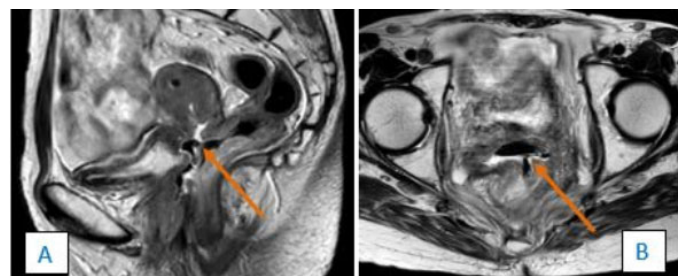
Pelvic MRI in T2-weighted sagittal (A) and axial (B) sections, in a 52-year-old patient with a history of cervical cancer treated with concomitant radio-chemotherapy, showing a fistulous pathway (arrow), communicating the rectum and the vaginal lumen.
